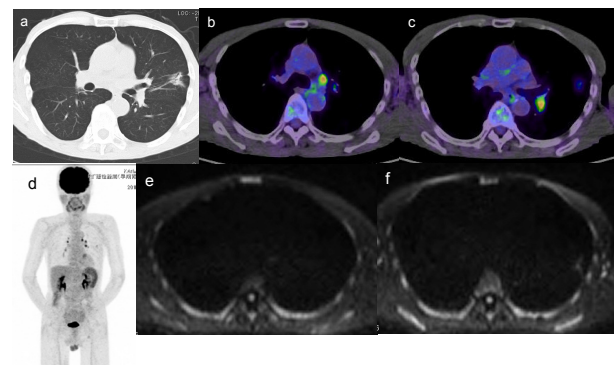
74 y.o. Male with Pulmonary Adenocarcinoma, but Without Lymph node Metastasis. The patient was diagnosed correctly by DWI, not by PET-CT. The patient was diagnosed as n2 disease by PET-CT, but n0 disease by DWI. Lymph node station #4L was diagnosed positive by PET-CT (b), but negative by DWI (e). Lymph node station #11 was diagnosed positive by PET-CT (c), but negative by DWI (f). The lymph node stations were diagnosed as sarcoidosis pathologically
